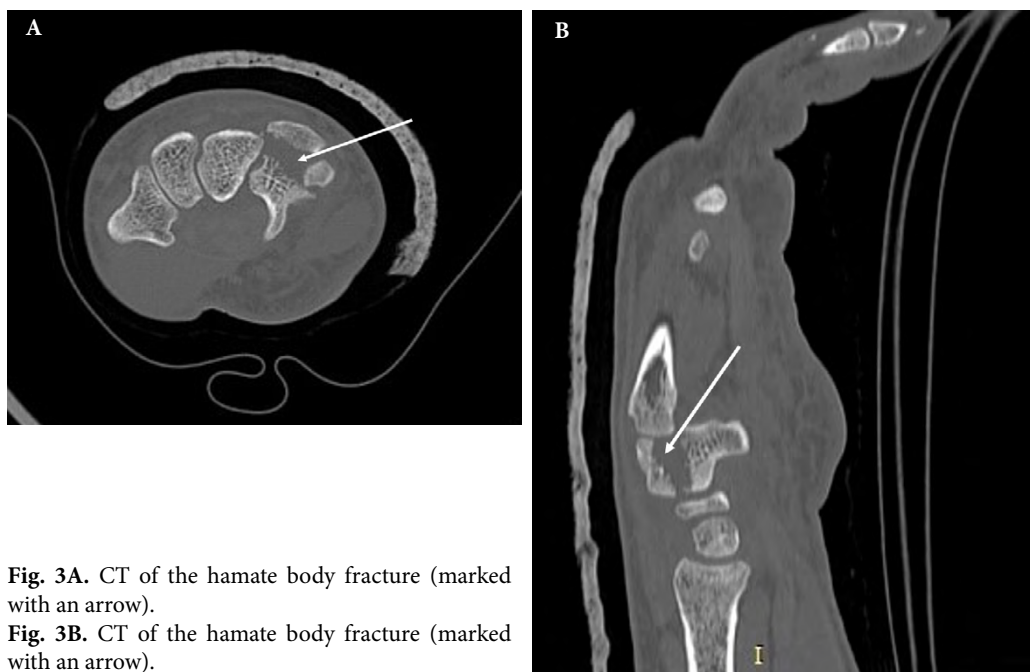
CT of the hamate body fracture (marked with an arrow).
